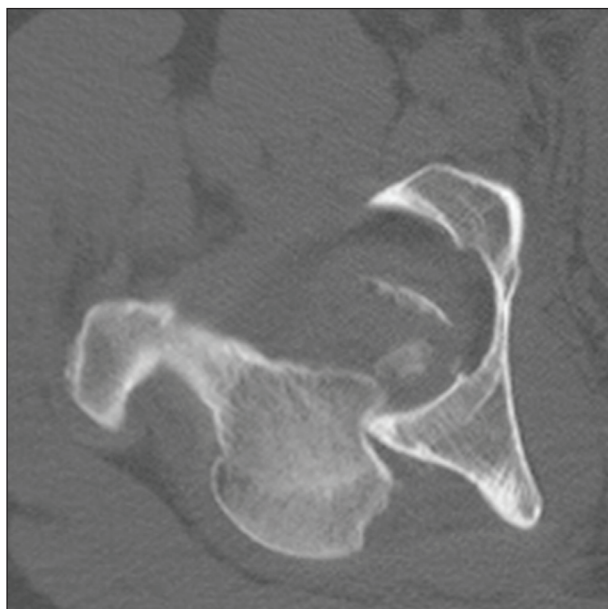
CT-scan slice showing femoral head impaction against the acetabulum.
